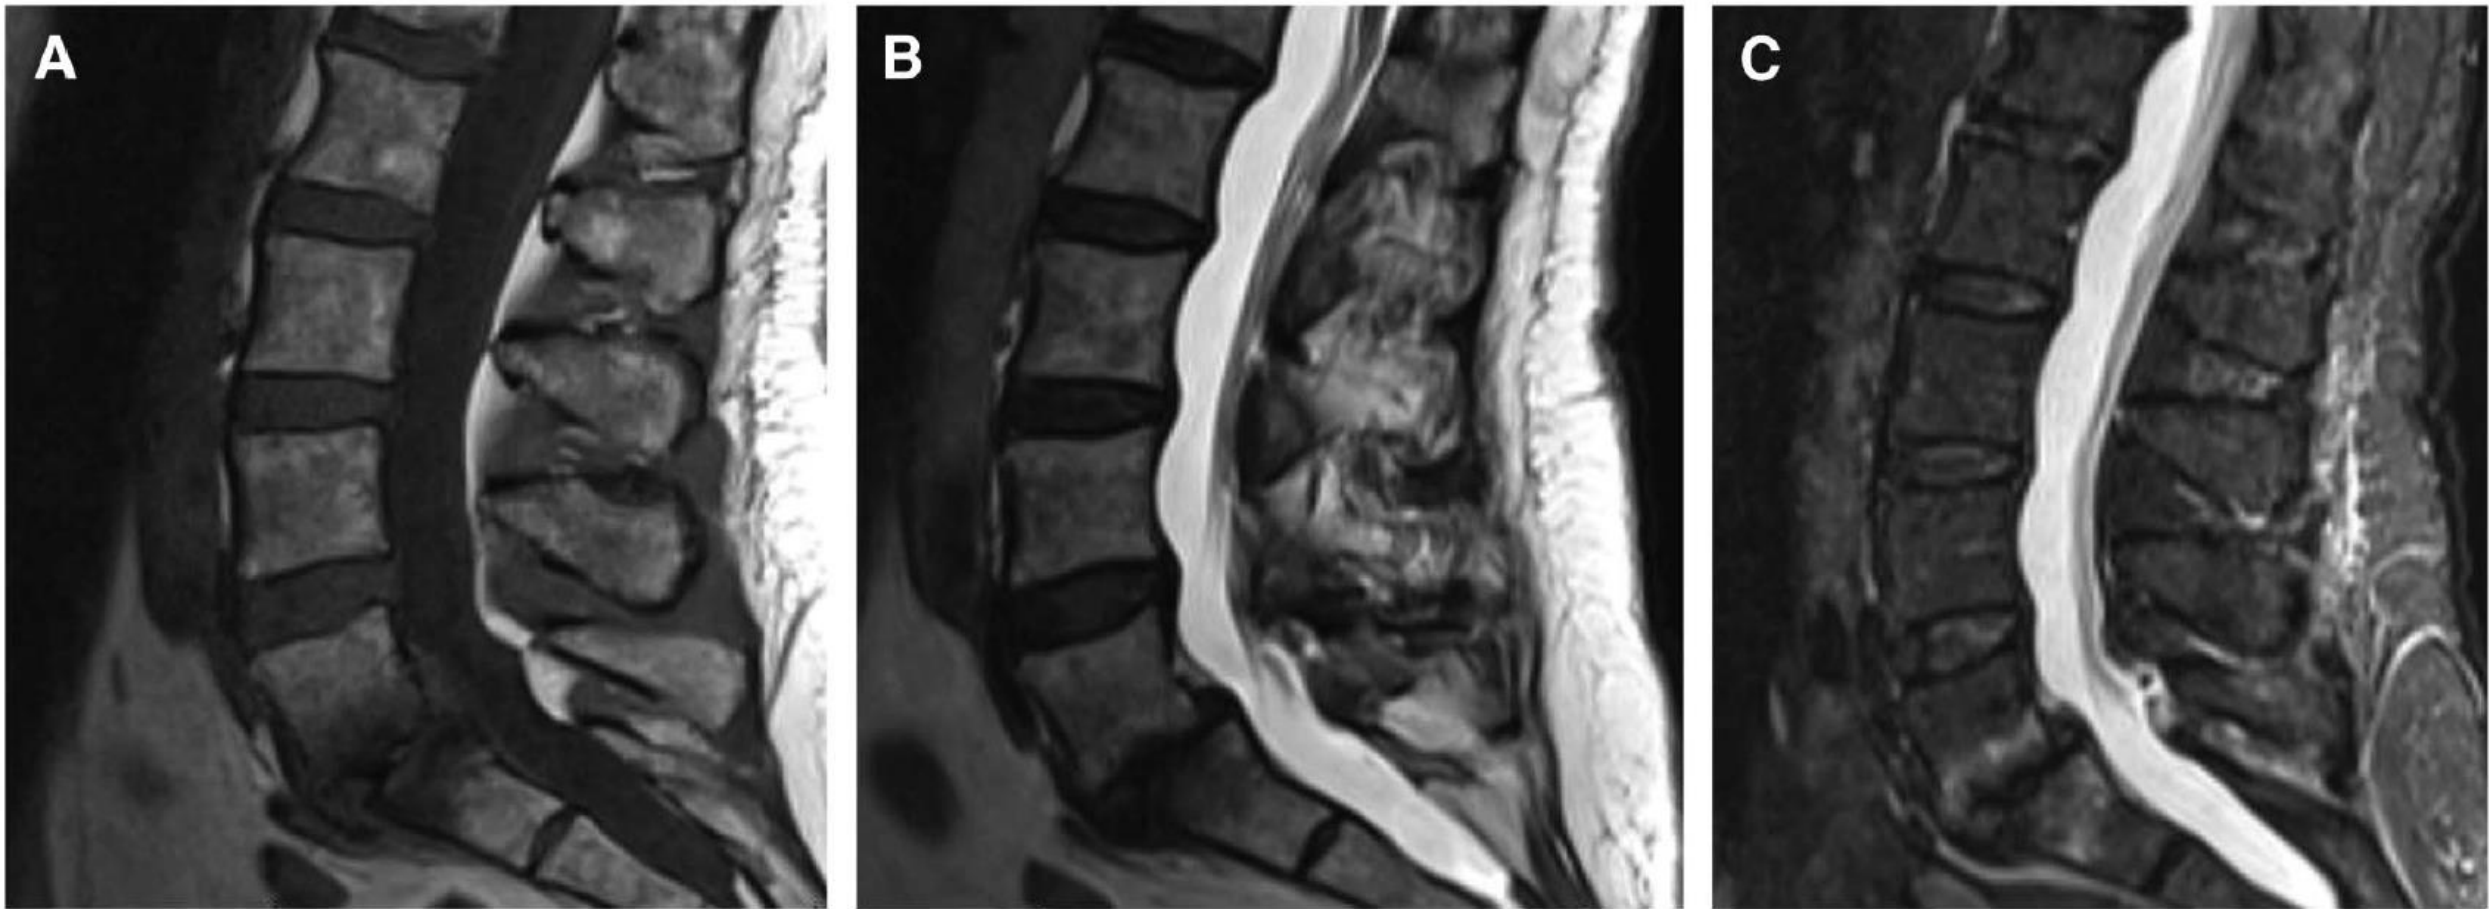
Sagittal (A) T1-weighted, (B) T2-weighted, and (C) STIR images of the lumbar spine exhibit type 1 fibrovascular endplates changes at L5-S1 with hypointense T1, heterogeneously hyperintense T2, and hyperintense STIR signal intensities.
